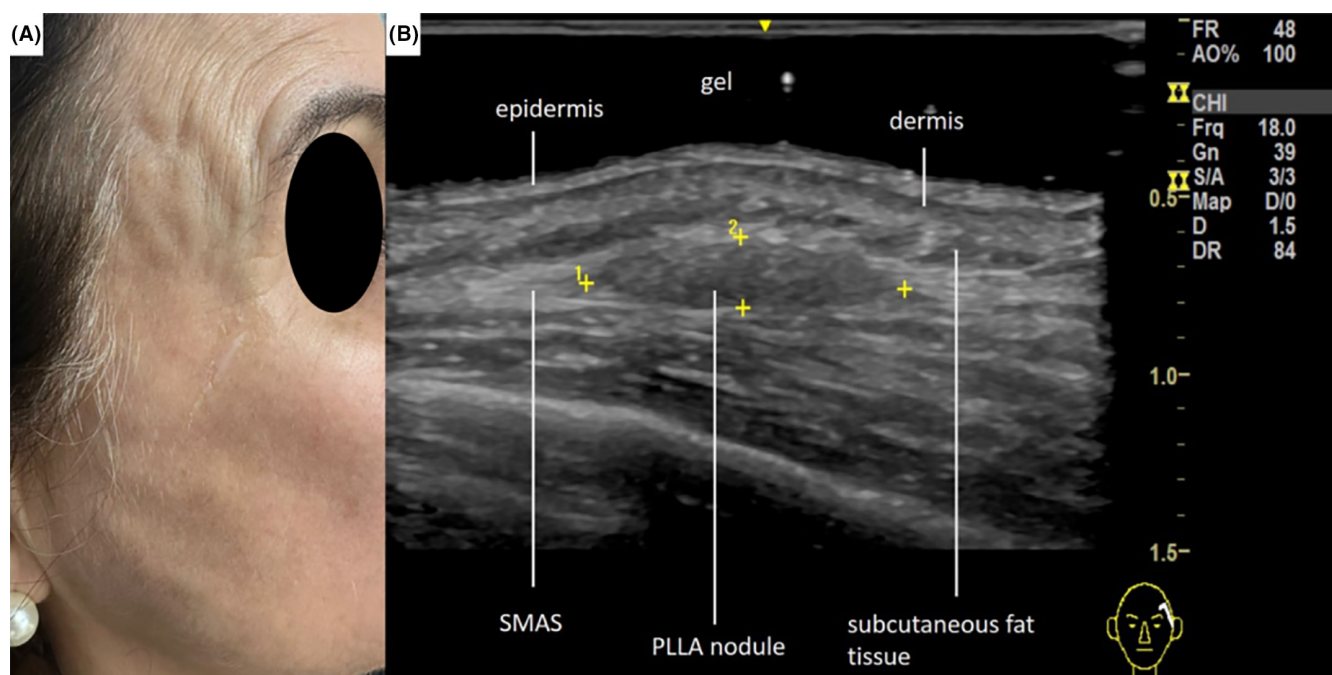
(A) Nodules of poly-L-lactic acid (PLLA-Sculptra®) in the temporal and parotidomasseteric region. (B) High-frequency grayscale ultrasound (18 MHz), longitudinal incidence, of another patient shows a hypoechoic nodule of PLLA (Sculptra®) in the SMAS, which was injected in the wrong plane.
